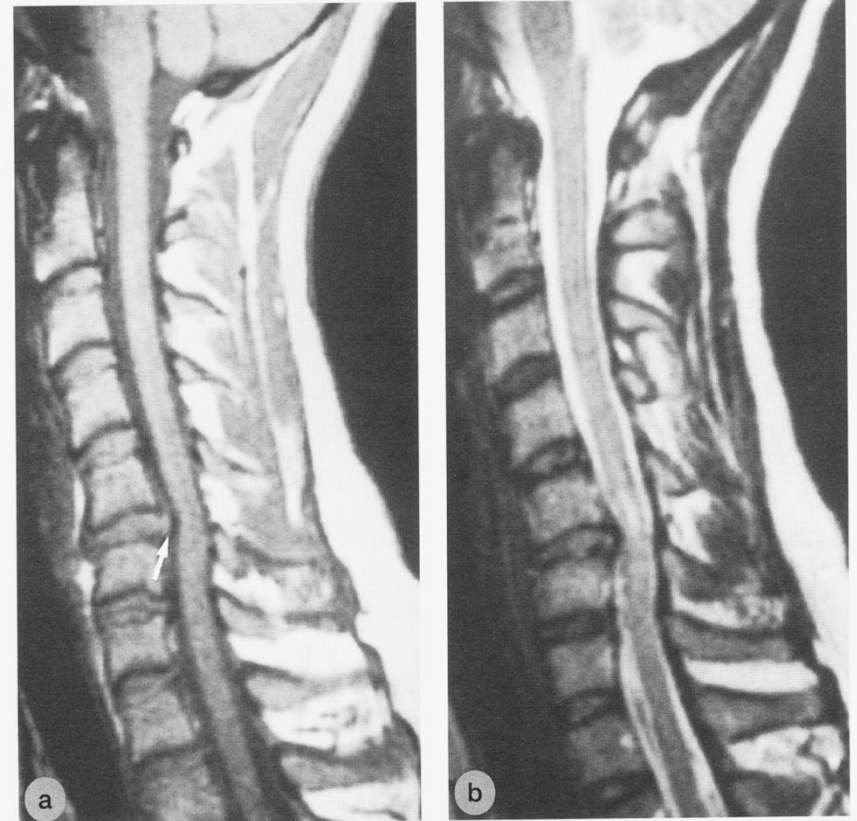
Traumatic cervical disc herniation. Sagittal short TR/short TE (T1-weighted) (a) and sagittal long TR/long TE (T2-weighted) (b) spin-echo MR images of the cervical spine. T1- and T2-weighted images demonstrate posterior extrusion of disc material causing compression of the cervical spinal cord (arrow). The T2-weighted sequence also demonstrates increased signal within the cervical cord indicating cervical cord contusion. There is effacement of the CSF space both anterior and posterior to the cord.
